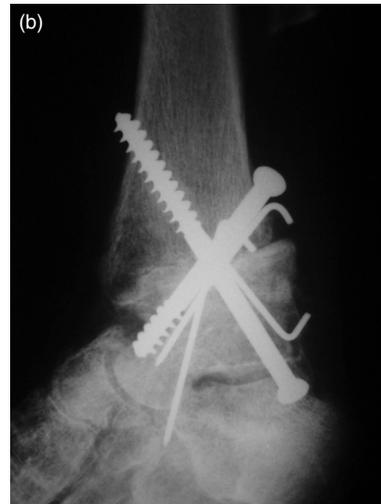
A, Preoperative radiograph of the ankle with arthritis and severe valgus deformity. B, Postoperative oblique view of the same ankle with arthrodesis, with the fibular graft bone block fixed with screws and Kirschner wires.
